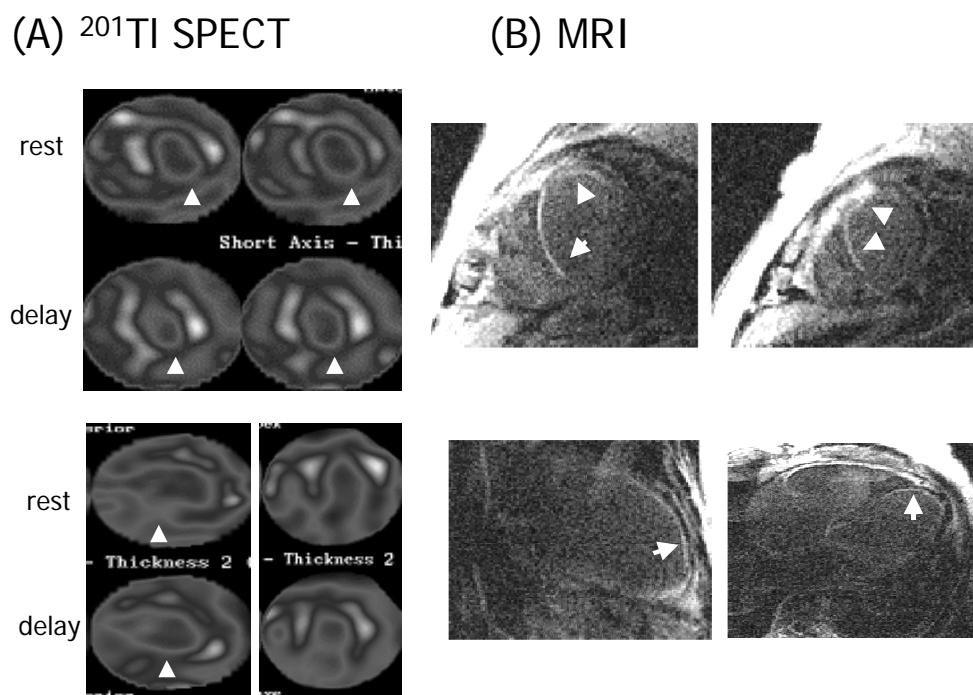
A 43-year-old man with 3-vessel disease (LVEF 8%) showed scar in the inferior wall (arrow heads) on the rest-redistribution  $^{201}\text{TI}$  SPECT (A), which is discordant with contrast-enhanced MRI (B) showing delayed enhancement in the anterior and septal walls (arrows)
